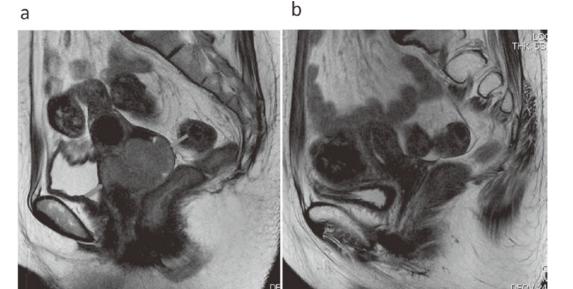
Therapeutic response following injection of the agent KORTUC II, as evaluated with magnetic resonance imaging examination of the reported patient. (a) T2-weighted magnetic resonance imaging of initial staging workup. Sagittal images shows a cervical mass (arrows). (b) Two months after treatment with KORTUC II; the cervical mass has almost completely disappeared.
